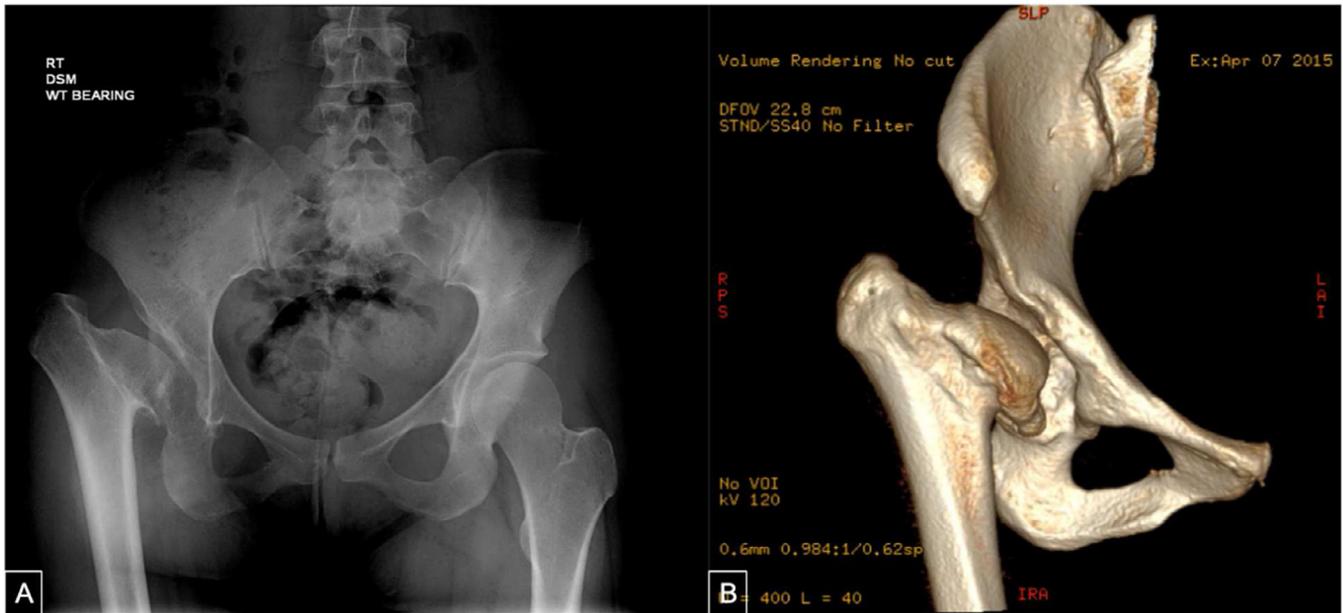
A 26-year-old female with DDH. (a) Radiographs and (b) computed tomography (CT) scan reveal femoral head avascular necrosis with a shallow, anterosuperiorly deficient acetabulum.
